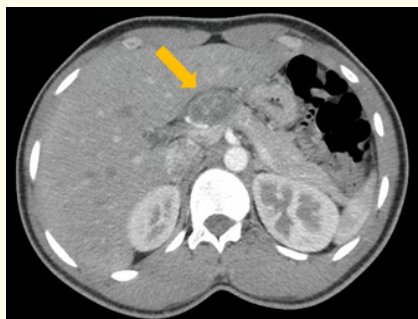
CT scan showing abnormal abdominal lesion.
